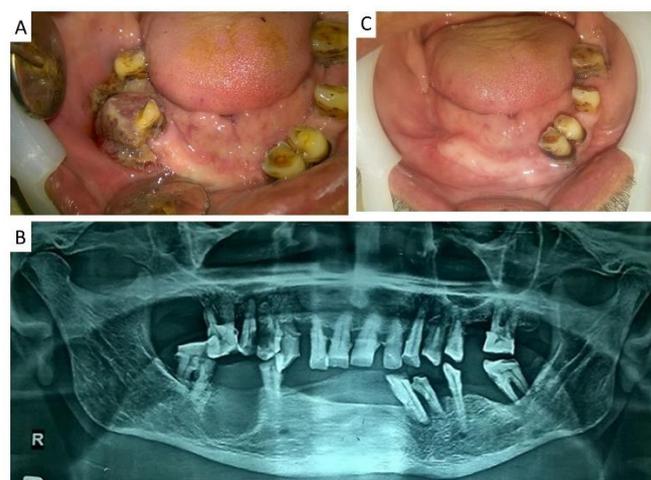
A) Growth in the right mandibular posterior region; B) Orthopantomogram showing a well-defined lytic lesion of about 3 cm with smooth corticated border; C) Post-operative follow-up after 6 months
